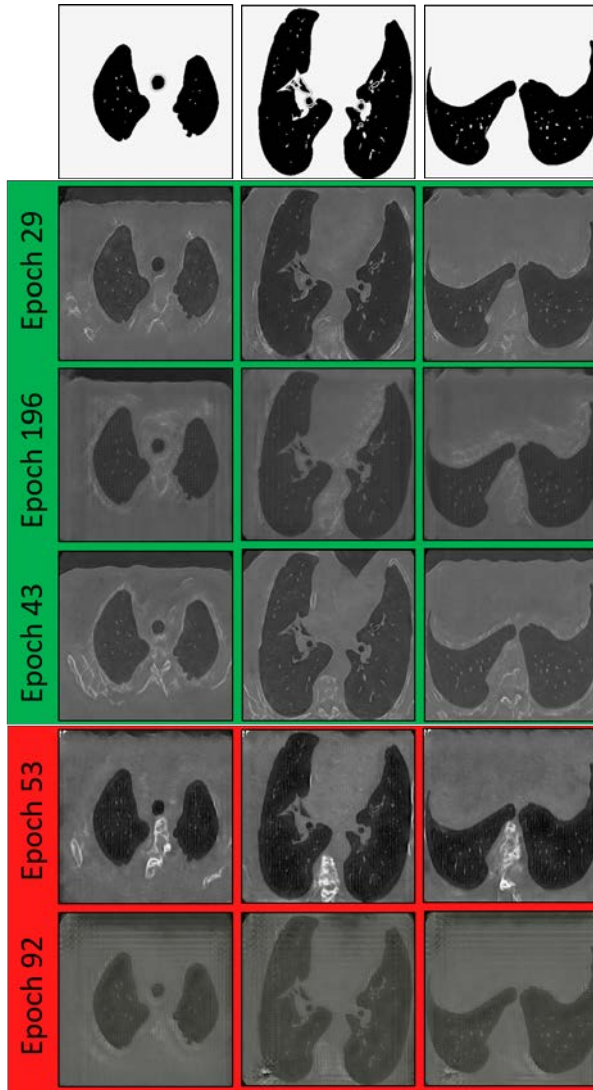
Generated CT virtual scans for 3 representative CT segmentations (basal, mid and distal): images from Pareto front epochs in green frame and images from non-Pareto epochs in red one.
